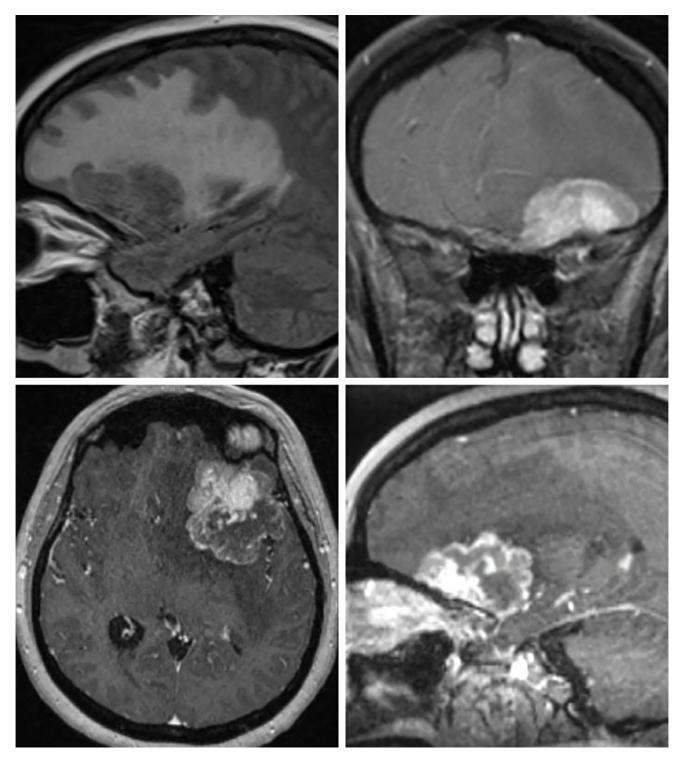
(Top Left) This dura-based metastasis along the inferior aspect of the left frontal lobe is causing a tremendous amount of hyperintense edema on this sagittal FLAIR image. Coronal (top right), axial (bottom left), and sagittal (bottom right) postcontrast T1-weighted images show this lesion to have bright enhancement and a broad dural base, a finding more typically seen with meningioma, a common mimic of metastatic disease.
